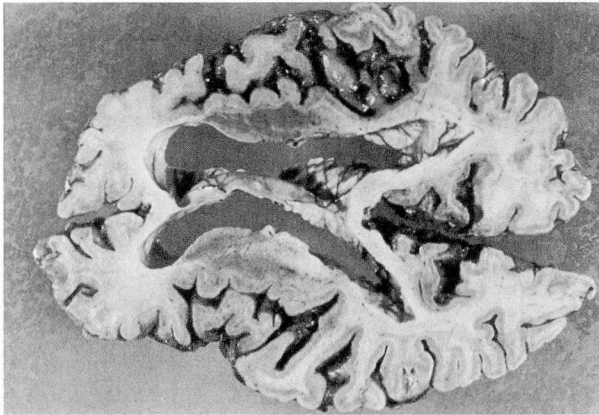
Computed tomographic plane section of brain showing prominent cortical atrophy with narrowing of gyri, widening of sulci, and ventricular dilatation.
